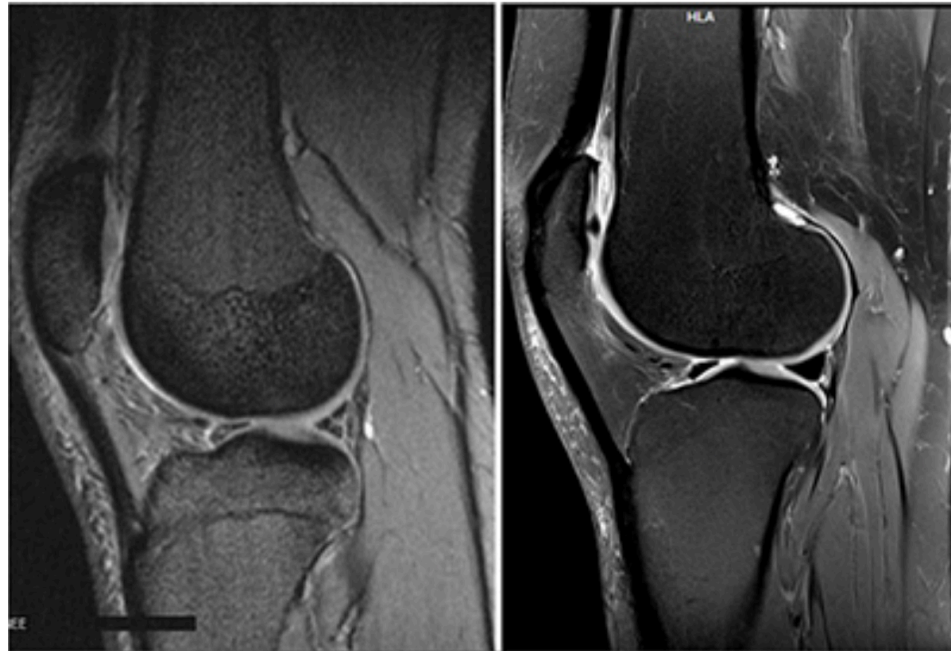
Comparison of image quality of two MRI scans in DICOM format: 1.5 T image (left) versus 3.0 T image right (modified from iseh.co.uk); DICOM, Digital Imaging and Communications in Medicine.
